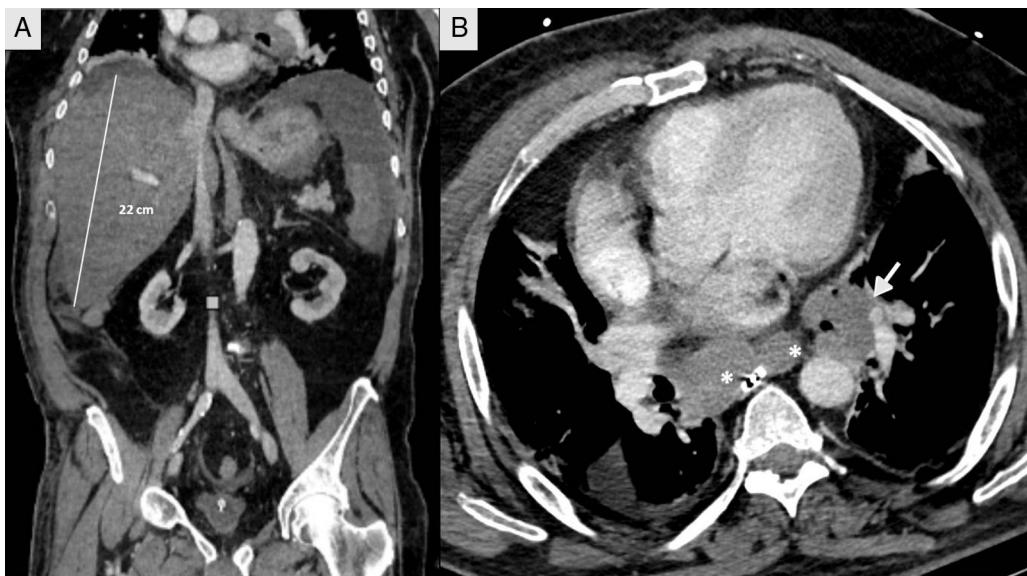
Thoracic/abdominal multi-slice CT with IV contrast. (A) Axial section of the thorax showing enlarged lymph nodes in the subcarinal region (*) and left hilar region (white arrow). (B) Coronal section showing a large homogeneous hepatomegaly.
